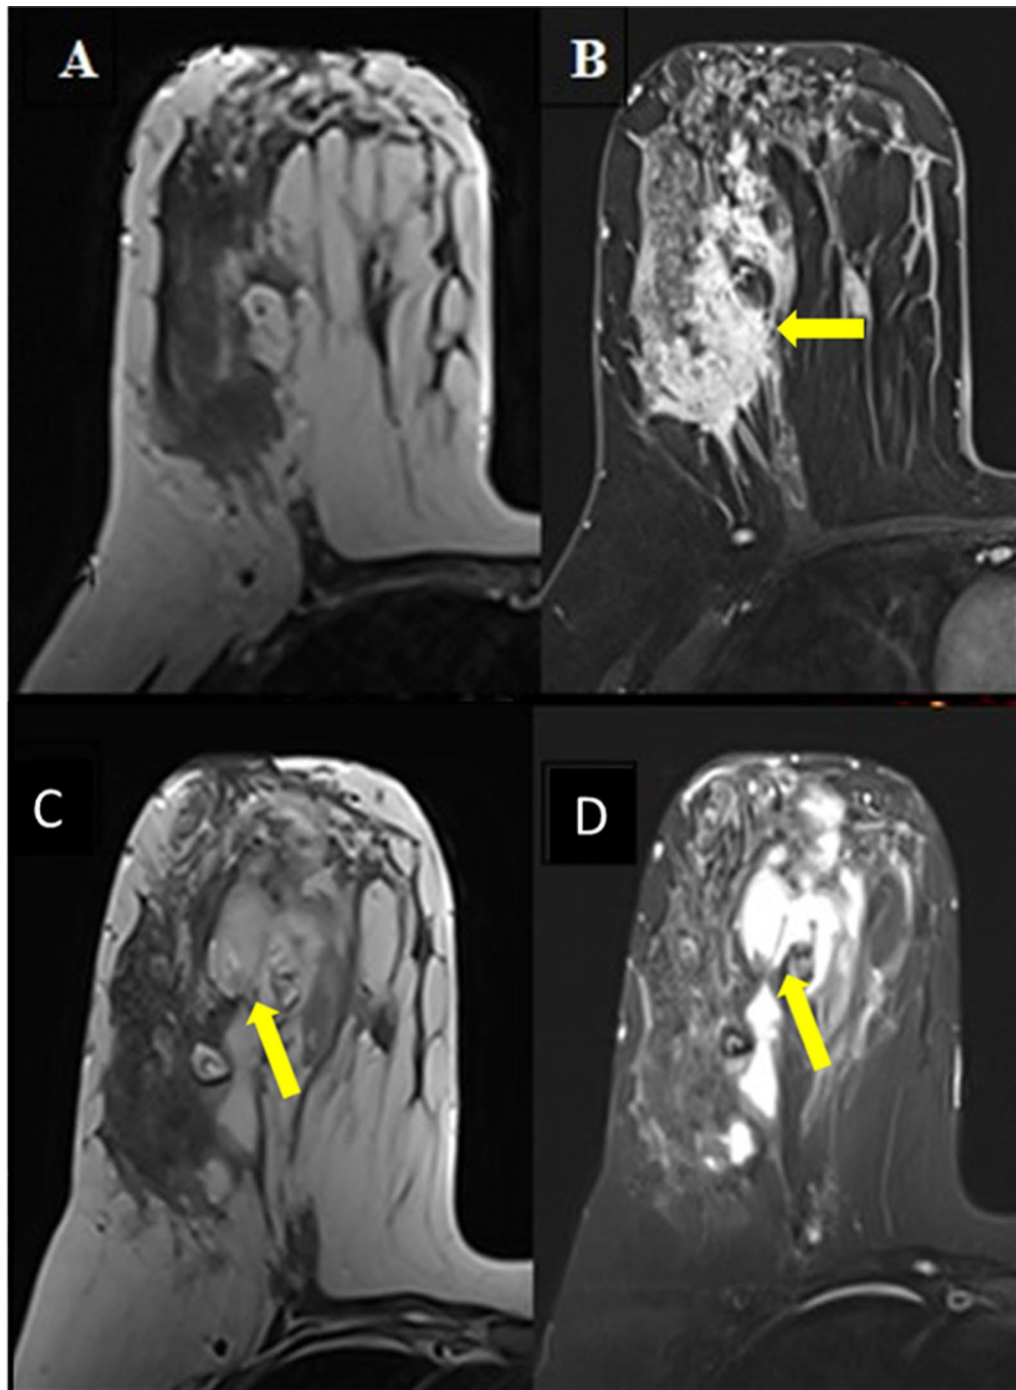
A 35-year-old female with right breast swelling and tenderness. Pathology revealed benign pathology; non-specific granulomatous mastitis. MRI examination was done at an early stage of the disease process after resistance to antibiotic treatment. A Axial T2-weighted image shows regional area of low signal intensity with corresponding intense heterogeneous non-mass enhancement (arrow) in the post-contrast dynamic series (B) and was considered suspicious (false positive). Follow-up non-contrast MRI examination by axial T2- and STIR-weighted images (C and D) shows the development of ill-defined fluid collections (arrows), consistent with a benign inflammatory process (true negative)
